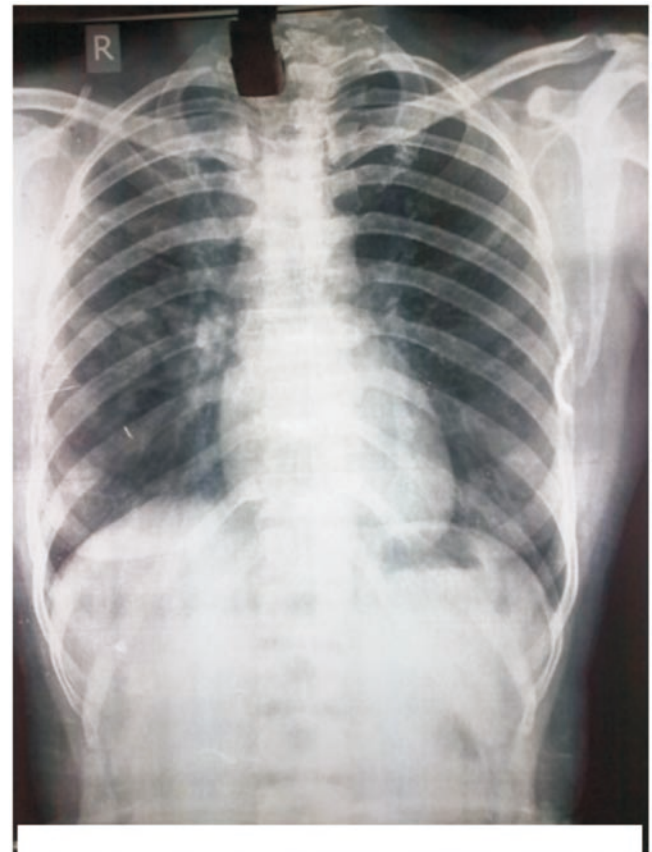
Chest radiograph posterior view after 4 months of itraconazole therapy (significant radiological resolution).
